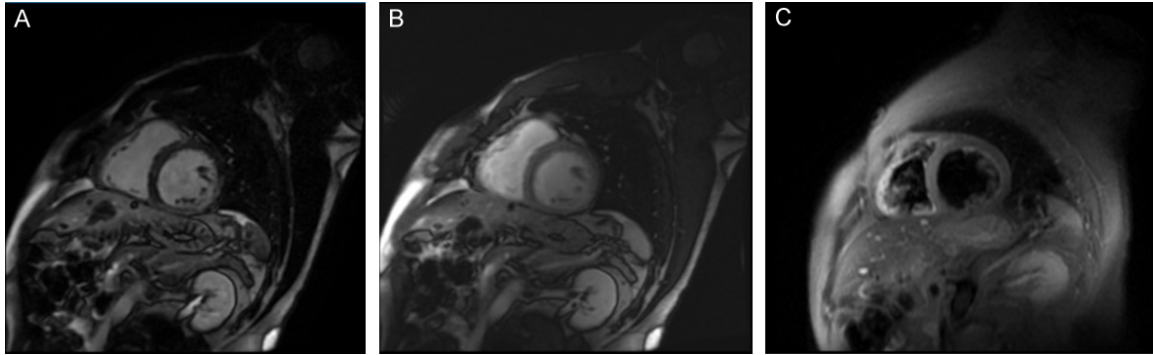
Acquisition protocol: MRI was performed on 1.5T MRI scanner (Optima MR450w, GE-Healthcare, Milwaukee, WI) using a dedicated cardiac phased array coil. Imaging sequences included black blood single-shot fast spin echo, bright blood balanced steady-state free precession gradient echo, T1 weighted inversion recovery early gadolinium enhanced (EGE) and late gadolinium enhanced (LGE) imaging. EGE and LGE were obtained 3 minutes and 7-10 minutes after single dose (0.1 mM/kg) of gadobenate dimeglumine (MultiHance, Bracco, Monroe Township, NY) intravenous contrast, respectively. A: LGE short axis image demonstrates mid LV anteroseptal, inferoseptal midwall and inferior, inferolateral wall subepicardial enhancement. B: EGE short axis image demonstrates mid LV anteroseptal, inferoseptal midwall and inferior, inferolateral wall subepicardial enhancement suggesting hyperemia. C: T2-weighted black-blood short axis image demonstrates mid LV anteroseptal, inferoseptal, inferior and inferolateral wall edema.
